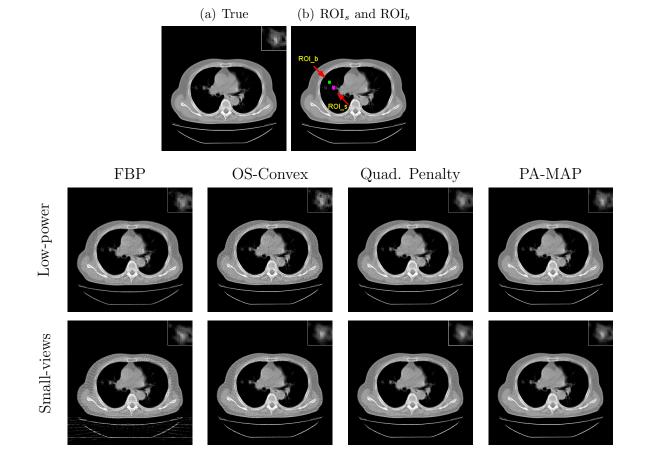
True image for patient #17 (slice #11) with calcification in left-side lung. (b) a guide mask for ROI_s and ROI_b regions. The bottom two rows show the reconstructed images for the cases of low x-ray power and small-views, respectively. The columns correspond to the FBP, OS-Convex, Quadratic Penalty and PA-MAP reconstruction methods. Magnification of the calcification region (ROI_s) is shown at the top right corner of each image. Background region (ROI_b) is not magnified as it contains no visual structures within the display gray scale.
